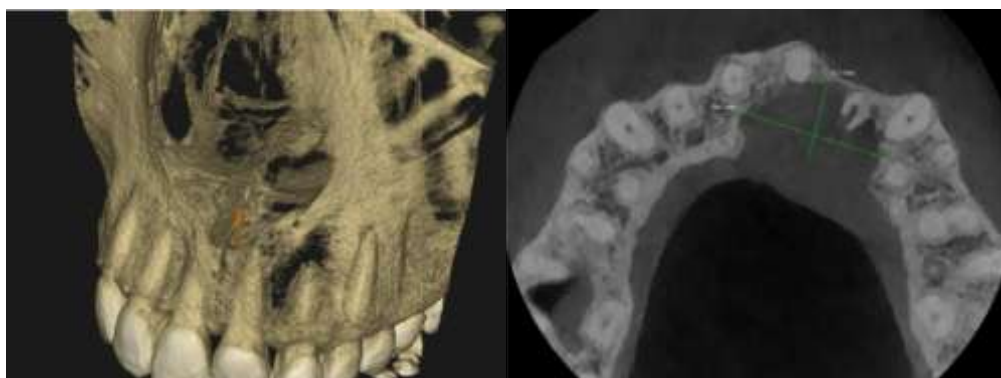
CBCT examination showing well defined unilocular hypodensity extending from 11 to 23 along with palatal plate perforation
